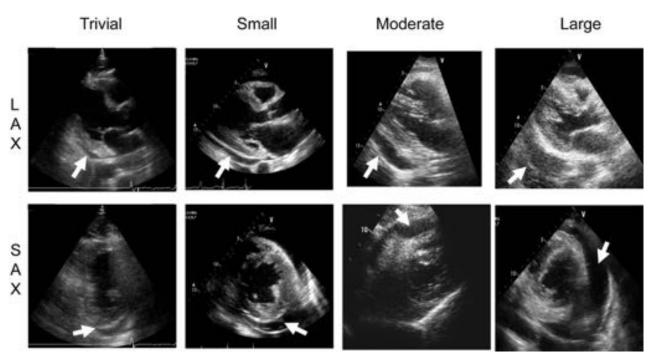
Representative trivial (Videos 4 and 5; available at www.onlinejase.com), small (Videos 6 and 7; available at www.onlinejase.com), moderate (Videos 8 and 9; available at www.onlinejase.com), and large (Videos 10 and 11; available at www.onlinejase.com) PEff sizes, parasternal long axis (top) and parasternal short axis (bottom).
